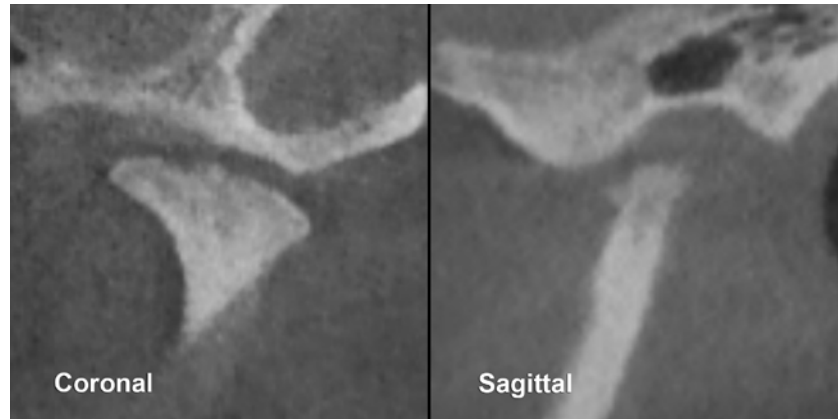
Coronal and sagittal CBCT images showing condylar sclerosis, erosion and resorption
